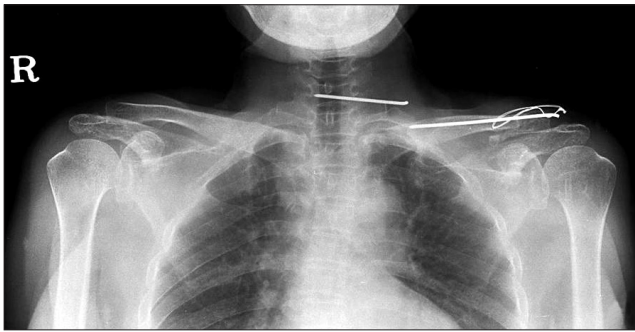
Plain radiograph shows the migration of one wire.
